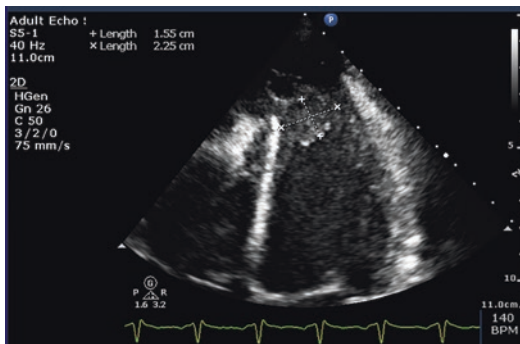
A 2D transthoracic echocardiography image of a primary left ventricular apical tumor which could not be differentiated from an apical left ventricular thrombus on echocardiography
